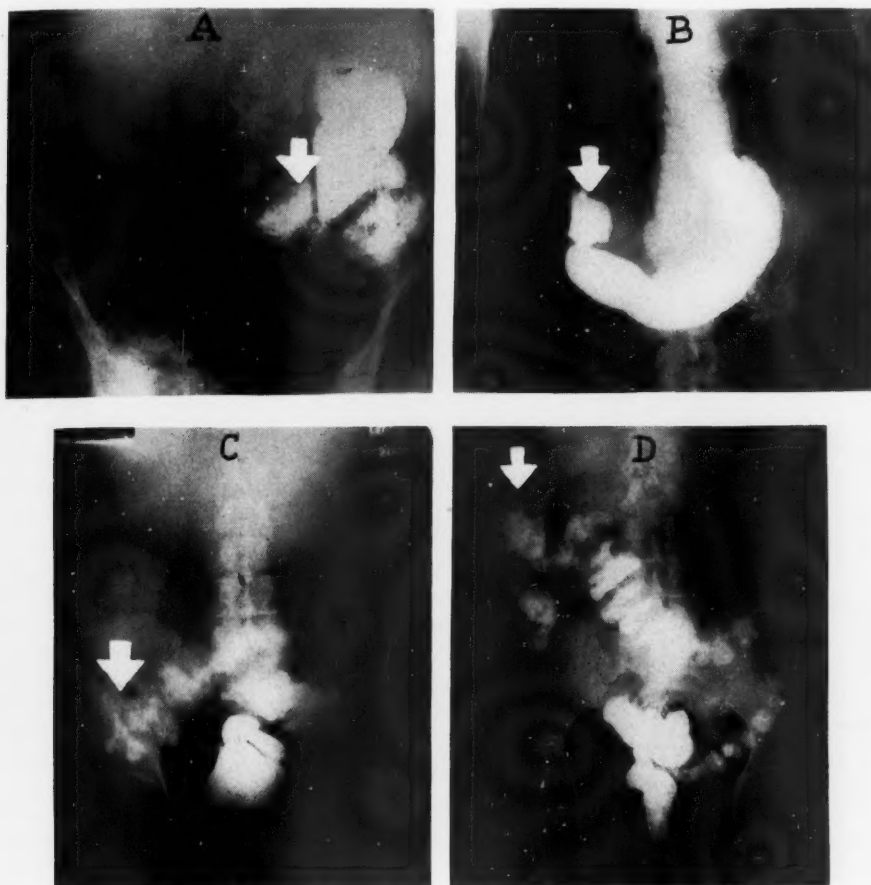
Roentgenologic studies in Case 2, in which the cyst was anastomosed to the duodenum. Arrow in (A) shows displaced stomach and duodenum preoperatively, and in (B) the return to normal position postoperatively. Arrow in (C) shows displaced hepatic flexure of colon preoperatively, and in (D) the return to normal position postoperatively.
